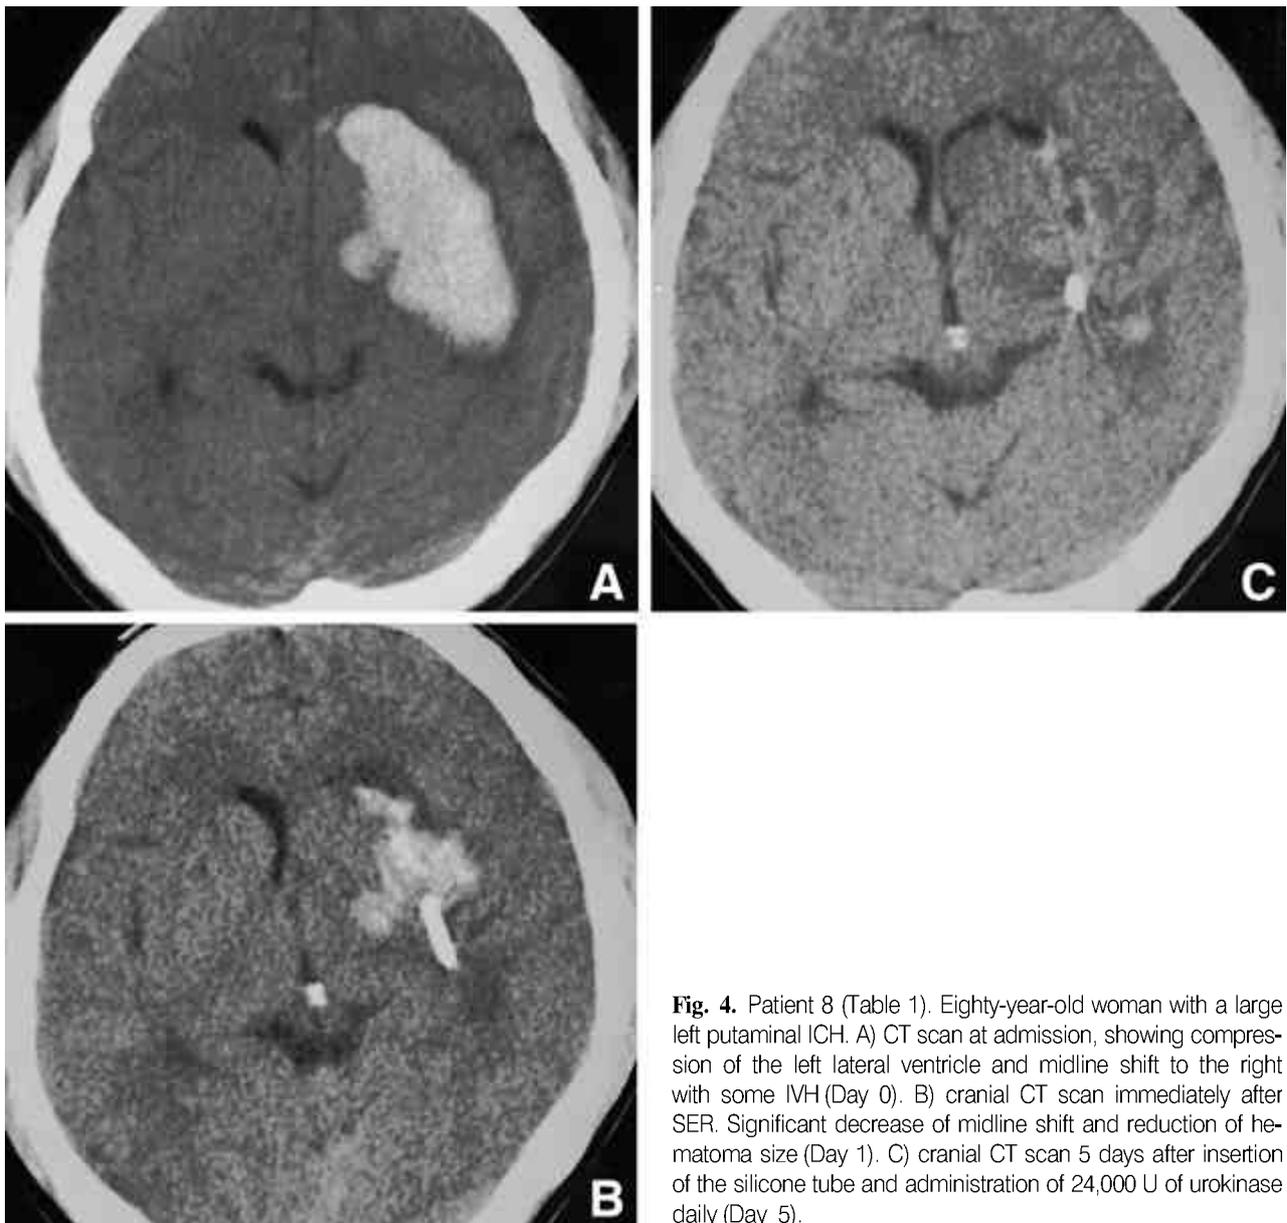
Patient 8 (Table 1). Eighty-year-old woman with a large left putaminal ICH. A) CT scan at admission, showing compression of the left lateral ventricle and midline shift to the right with some IVH (Day 0). B) cranial CT scan immediately after SER. Significant decrease of midline shift and reduction of hematoma size (Day 1). C) cranial CT scan 5 days after insertion of the silicone tube and administration of 24,000 U of urokinase daily (Day 5).
